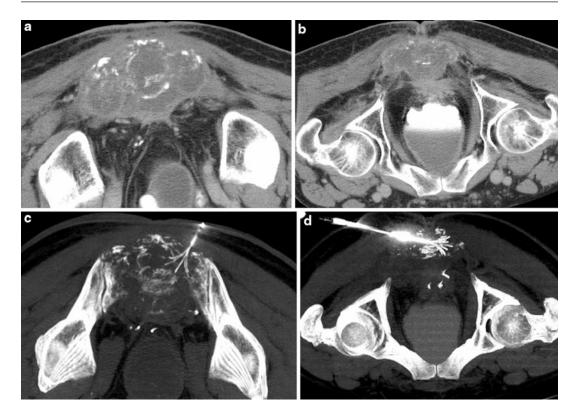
RF ablation of a large sacral metastasis. (a and b) Prone CT demonstrates near-complete replacement of the sacrum by metastatic rectal carcinoma. (c and d) RF ablation electrodes were deployed to 5 cm. These were two of seven electrode placements during the first of stage of treatment for the ablation of much of the caudal aspect of the osteolytic lesion. The second-stage treatment of the mid-sacrum was performed 6 weeks later. Patient was unable to sit prior to treatment and had resting pain
